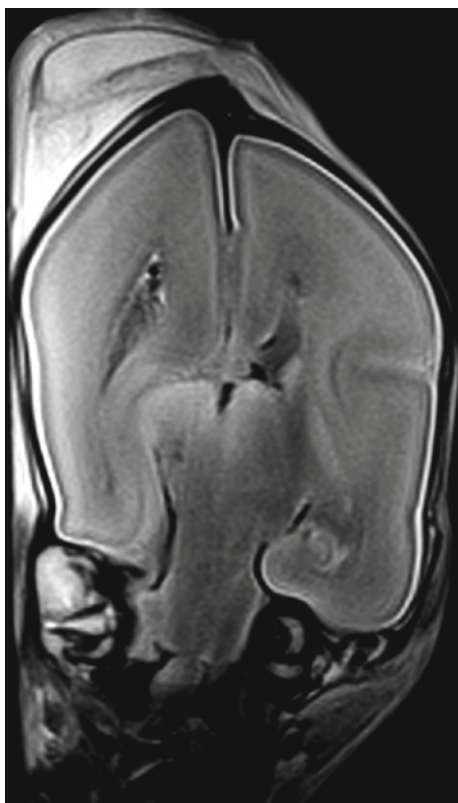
Coronal MR image of a 23-week gestation fetus
